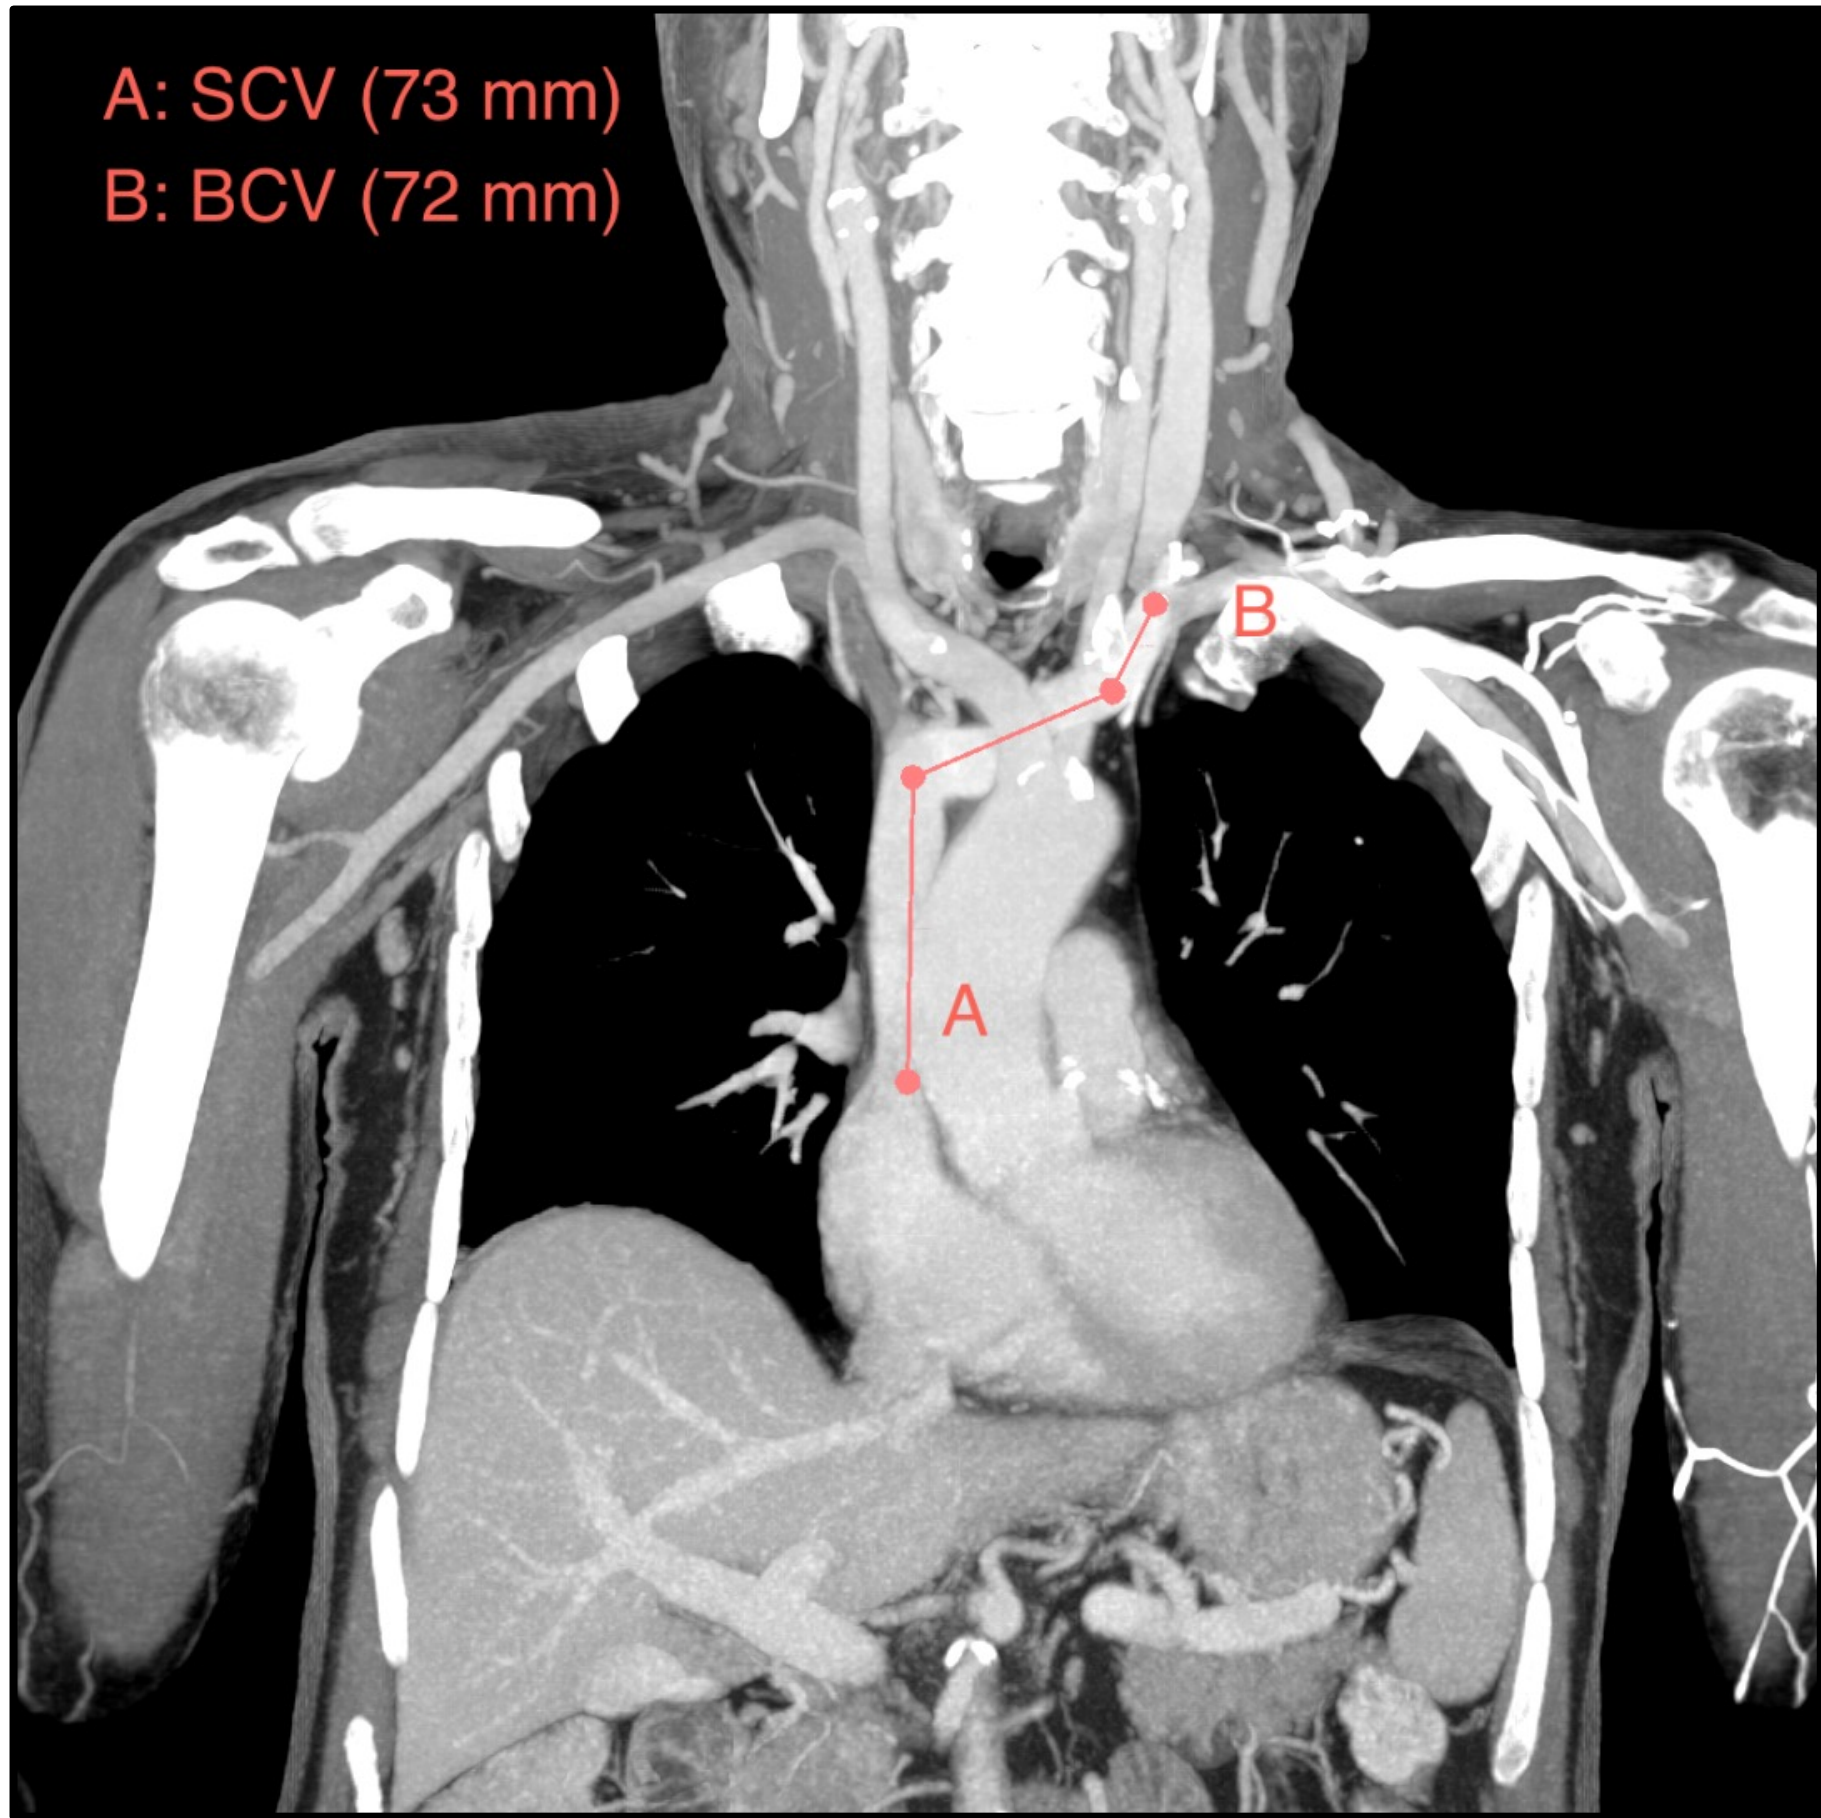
Measurement of the left brachiocephalic vein and the superior vena cava lengths through a standard ruler tool applied to the bidimensional CT scan slices (145 mm in this case).
